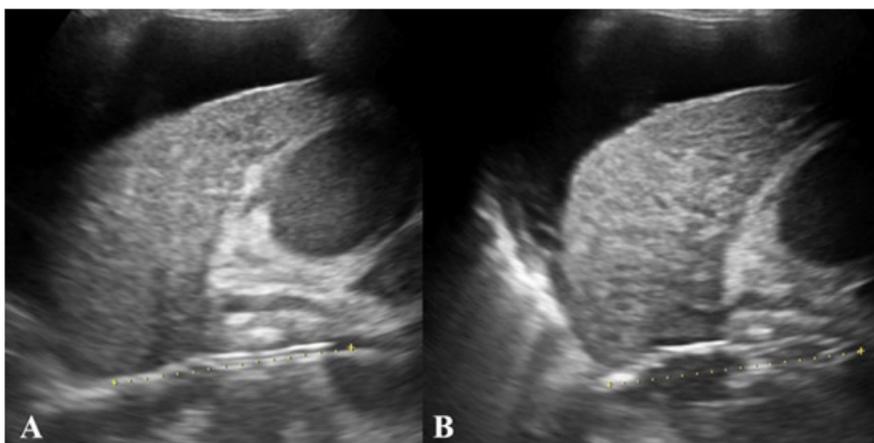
Measurement of the shunt by both sonogram. (A) Measurement of the shunt before the placement of metal stent on sonogram. (B) Measurement of the portosystemic stent after placement on sonogram.
